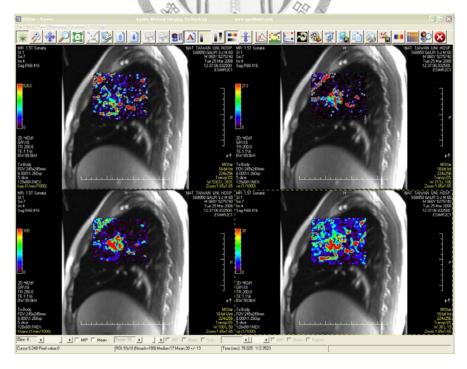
DCE-MRI parameter maps (upper right is v_e , upper left is k_{ep} , lower right is v_p , and lower left is k^{trans}).
